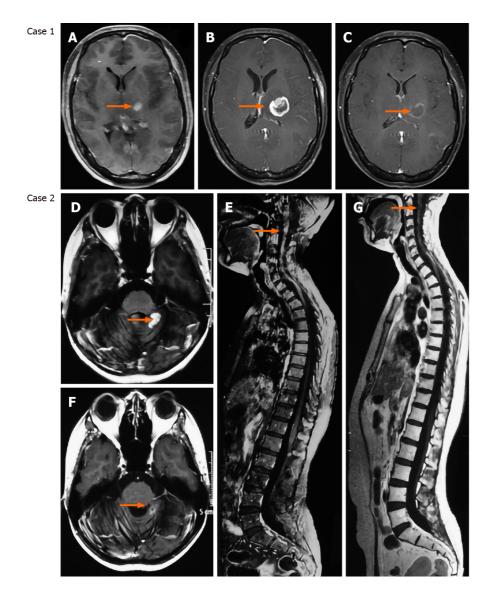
Targeting the vasculature presents promising effects on brain tumor therapy. Case 1 is a 29-year-old female patient who was diagnosed with IDH1/2 wild-type glioblastoma and received treatment of temozolomide combined with apatinib. Case 2 is a 31-year-old female patient who was diagnosed with recurrent medulloblastoma (local recurrence and dissemination) and received temozolomide + irinotecan + bevacizumab. A: Axial enhanced magnetic resonance imaging (MRI) showing a mass located at the left thalamus; B: Axial enhanced MRI showing that the lesion significantly progressed after 1-mo treatment of temozolomide; C: Axial enhanced MRI showing that the lesion was dramatically reduced after 1-mo treatment of combination of temozolomide and apatinib; D and E: Enhanced cerebrospinal MRI showing the local recurrent medulloblastoma and disseminated lesions along the spinal cord; F and G: Enhanced cerebrospinal MRI showing that the recurrent and disseminated lesions were significantly reduced after one cycle of chemotherapy.
